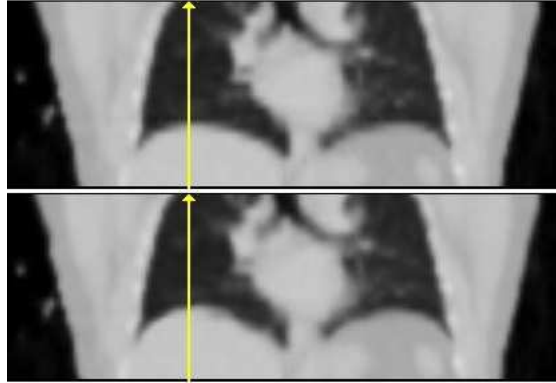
A coronal slice from the original CT based μ -map (above) and one transformed respiratory phase.
